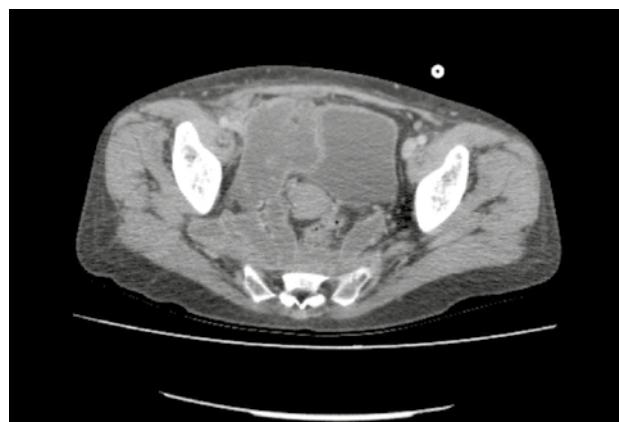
Contrast-enhanced CT image. Axial image of the pelvis.
